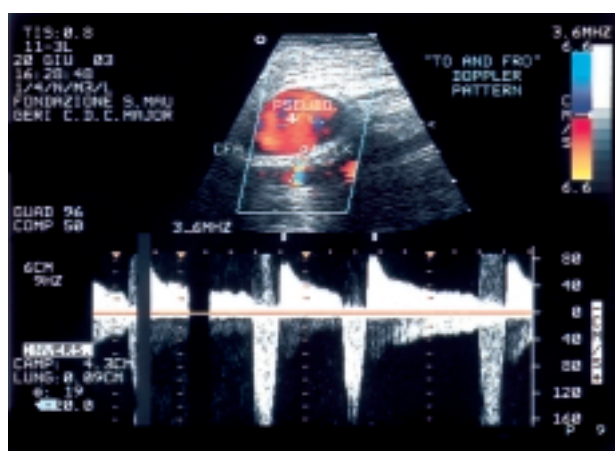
CFA = common femoral artery; NECK = pseudoaneurysm communicating tract; PSEUDO = pseudoaneurysm; TO AND FRO = pulsed Doppler pattern registered in the neck leading to the pseudoaneurysm.
